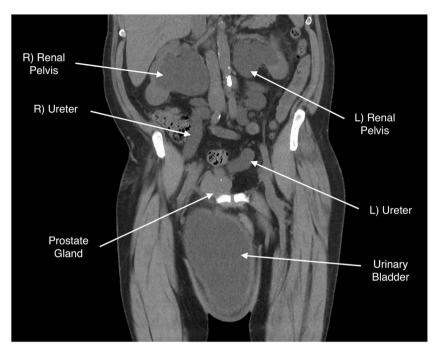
CT coronal image demonstrating herniation of the urinary bladder, with associated bilateral severe hydroureteronephrosis.
